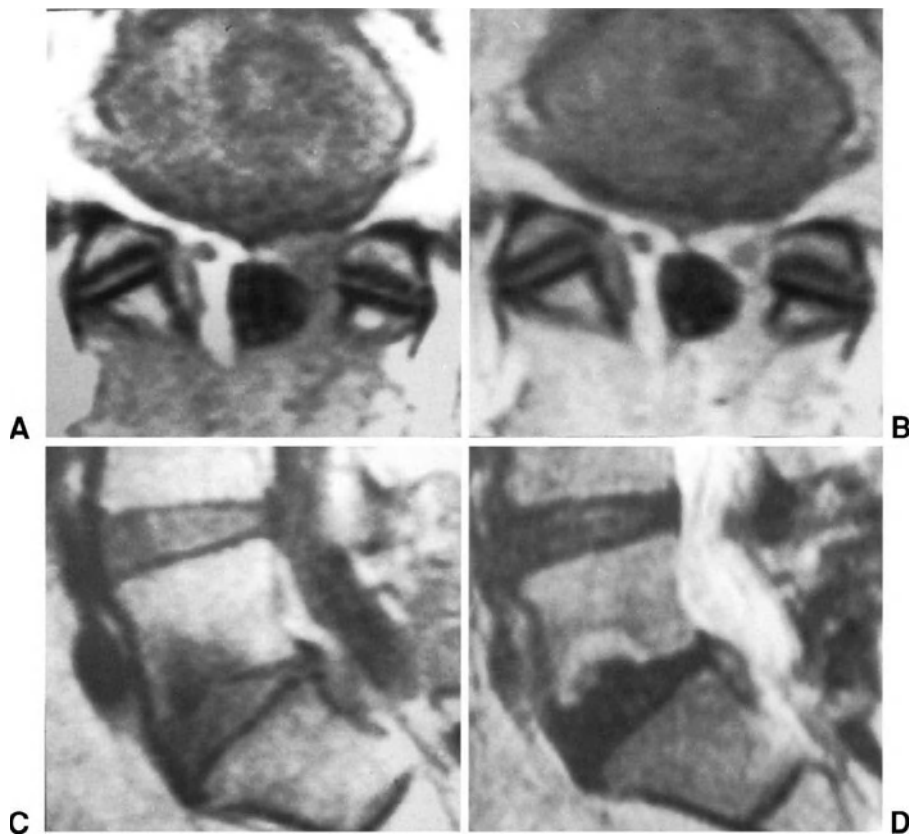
Abundant postsurgical fibrosis in a patient submitted to L5-S1 discectomy on the left. (A) and (B) Spin-echo T1-weighted axial MR images, respectively, without contrast medium and after administration of gadolinium. The scar tissue at the site of previous surgery is hypointense on the image without contrast; after gadolinium, the tissue displays a uniform increase in signal intensity and the nerve root becomes clearly visible. (C) and (D) Turbo spin-echo T2-weighted sagittal images, before and after injection of gadolinium, respectively. After gadolinium, the scar tissue becomes slightly hyperintense.
